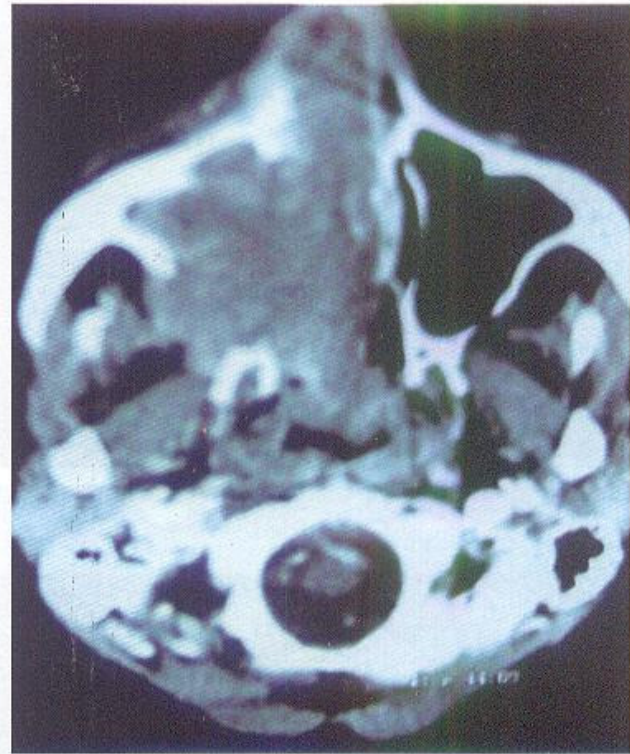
CT picture showing carcinoma maxilla right sided.
